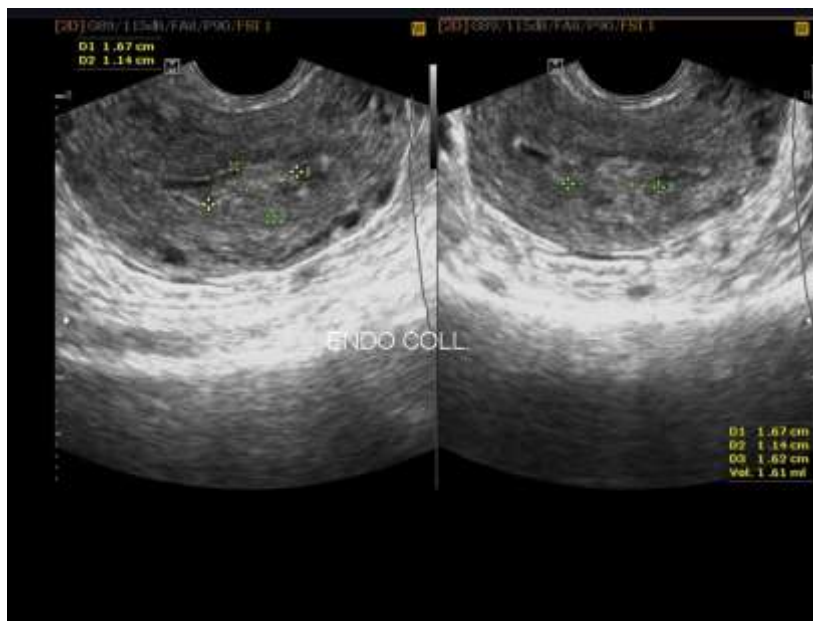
Ultrasound shows minimal endometrial collection but with absent IUCD in the cavity
